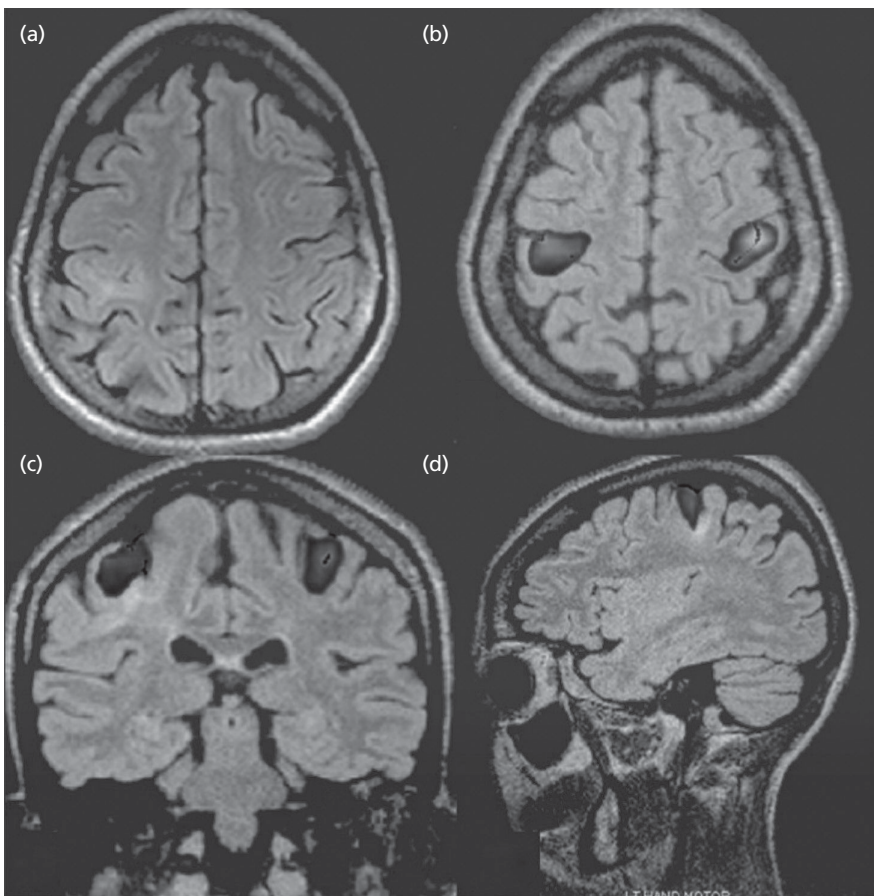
Functional MRI scan of brain activity with movements of the right and left hands showing finger tapping.
